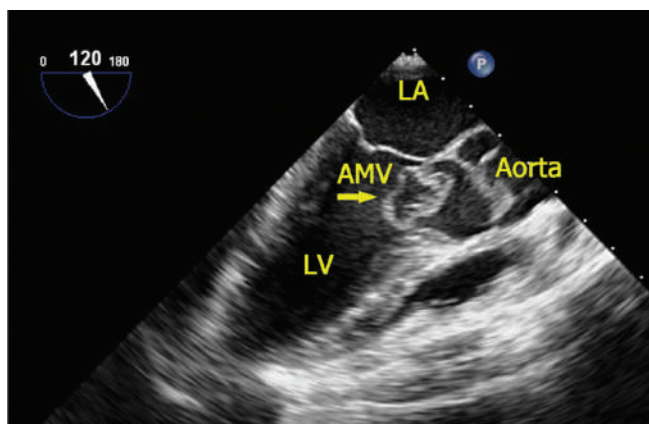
The image presents transesophageal echocardiography in the long-axis view. The arrow shows a large mass on the ventricular side of the anterior mitral valve leaflet during the systole. The aortic valve is bicuspid. LA, Left atrium; LV, Left ventricle; AMV, Accessory mitral valve
